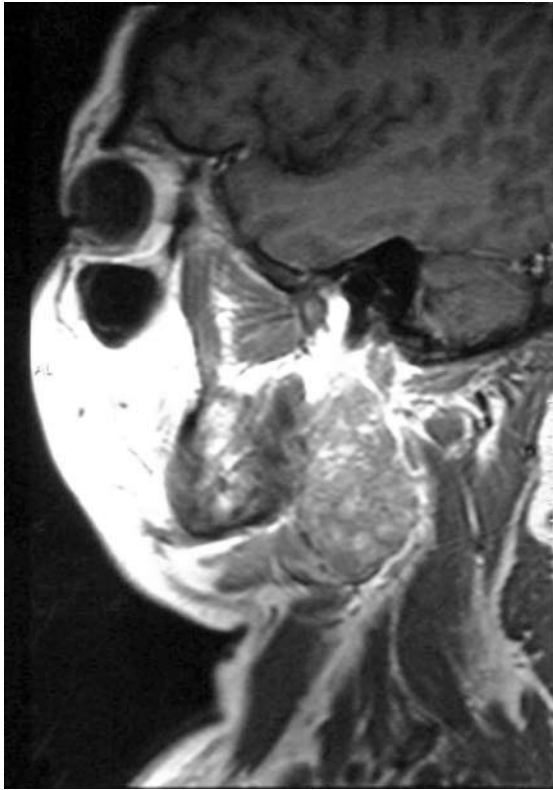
Sagittal T1-W MR image shows the thyroid tissue extending posteriorly and laterally to the prevertebral muscle.
